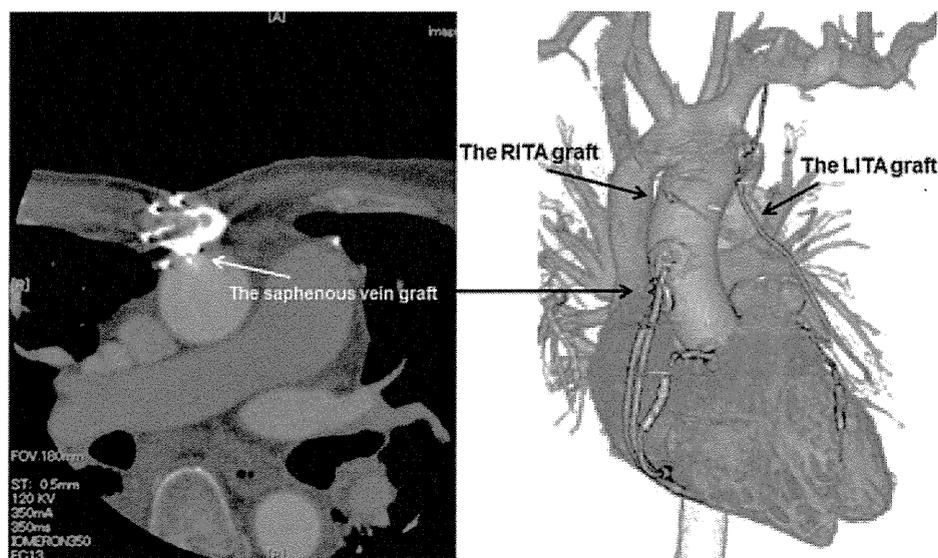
Preoperative computed tomographic images demonstrating the patent saphenous vein grafts adhering to the surgical wire, and the right internal thoracic artery (RITA) crossing the sternum at the midline. The left internal thoracic artery (LITA) is also patent.
